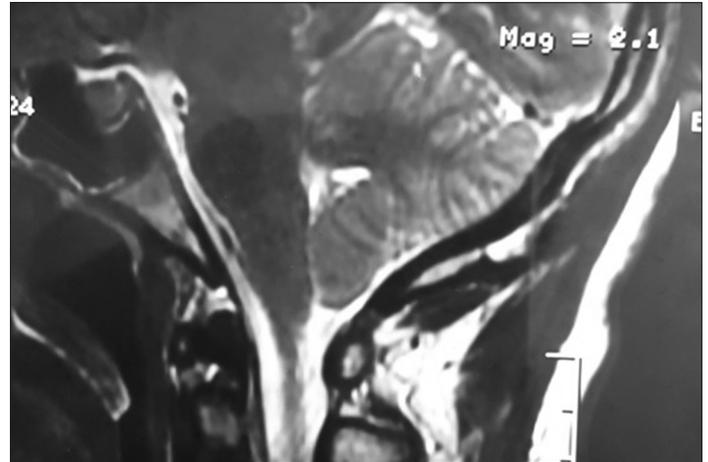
After performing a valveless lumboperitoneal shunt, the cerebral MRI in sagittal section showed an acquired Chiari malformation.
